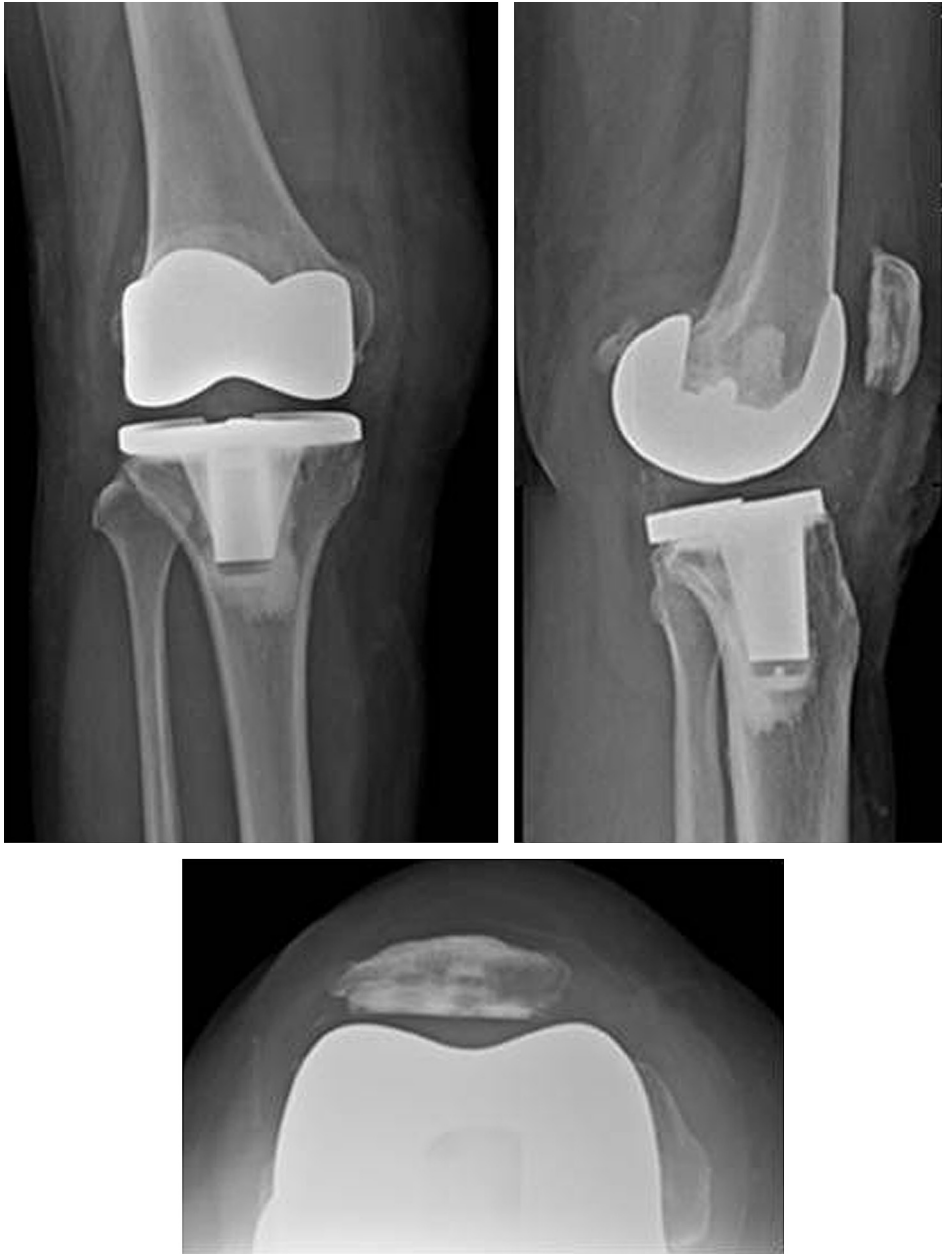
Radiographs after total knee arthroplasty and patellar component revision.
